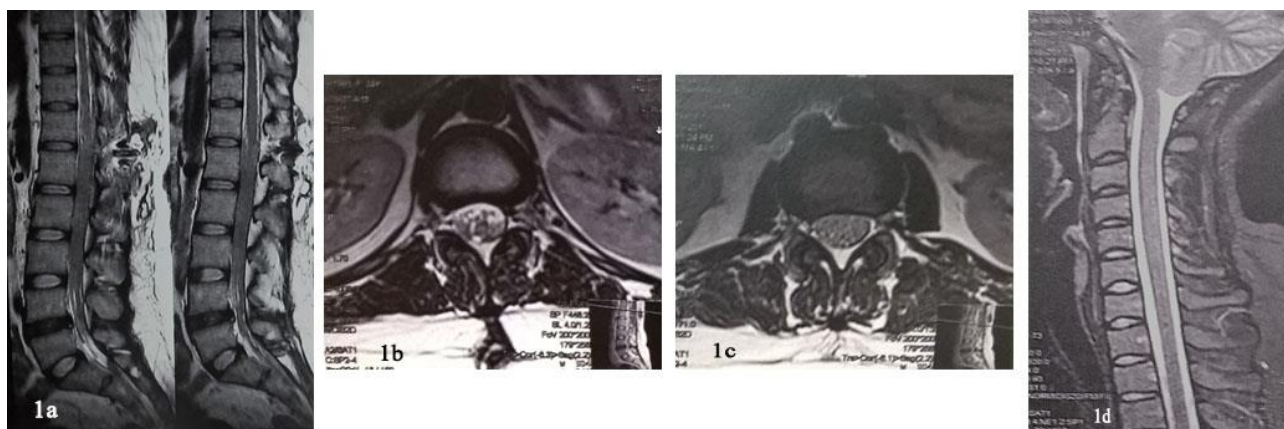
We can see sagittal (a) and axial views (b, c) of lumbosacral MRI that shows an entrance point of LP shunt at level of conus. Cervical (d) MRI of the patient revealed a 1-2 mm tonsillar descends
